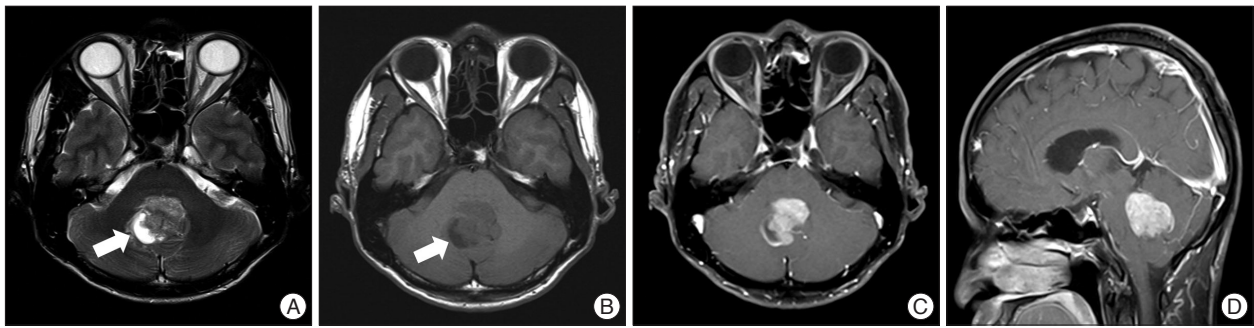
Magnetic resonance (MR) images of the lesion. T2-weighted (A) and T1-weighted (B) MR images showing a 3×3.5 cm sized relatively well-demarcated round mass in the fourth ventricle. The lesion had a cystic component isointense to cerebrospinal fluid (arrows in A and B). Postcontrast axial (C) and sagittal (D) MR images showing strong enhancement.
